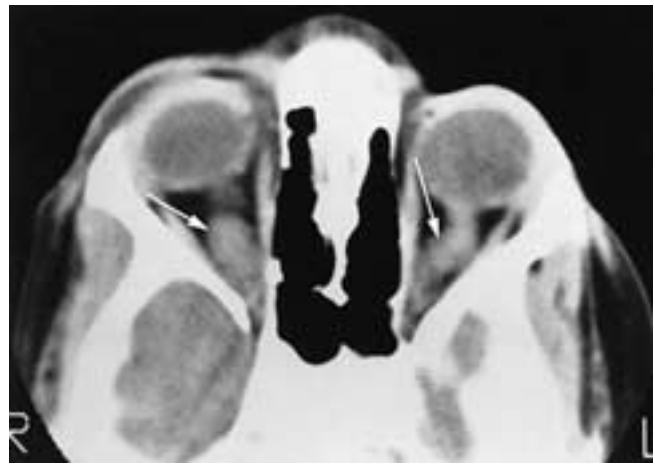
Axial CT scan. Neurofibromatosis with bilateral optic nerve gliomas (*arrows*).
